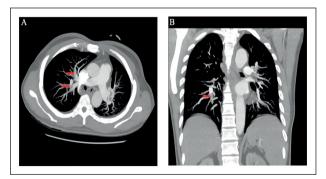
Pulmonary CTA performed after admission showing pulmonary artery thrombosis (red arrows).
